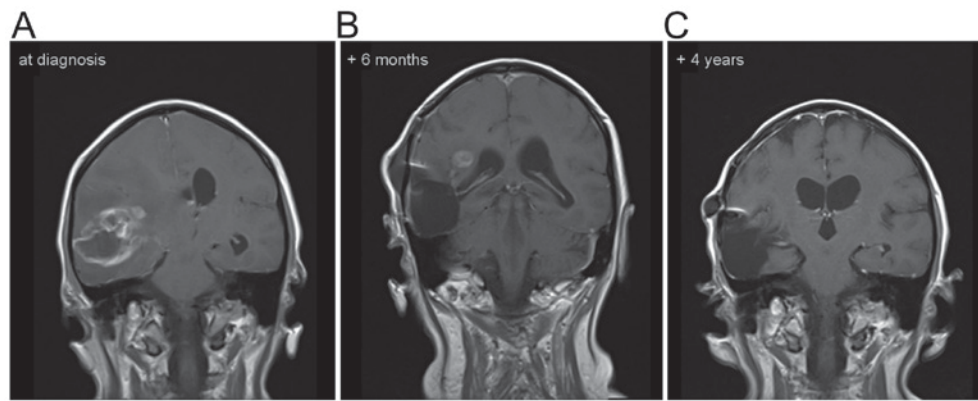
Sagittal MR T1-weighted images post gadolinium images of Patient No. 3 in whom the O₂-O₃ treatment was started following the initial surgery and diagnosis of (A) GB. Six months later, some contrast enhancement was still visible (B), that was not apparent four years following diagnosis (C).
